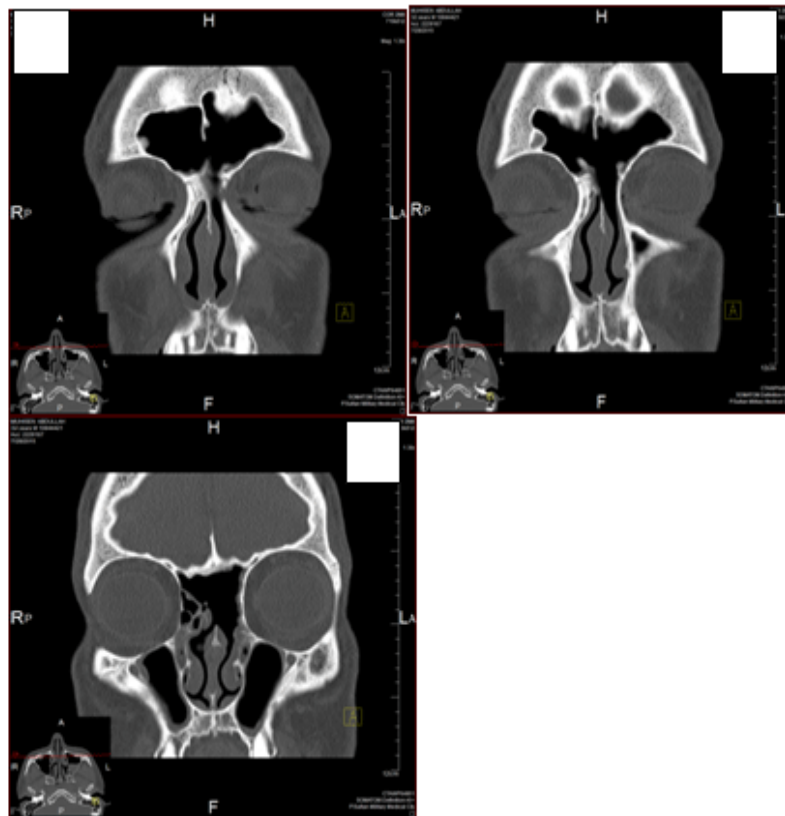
(2): Pre-operative CT coronal cut shows left frontoethmoidal mass.
